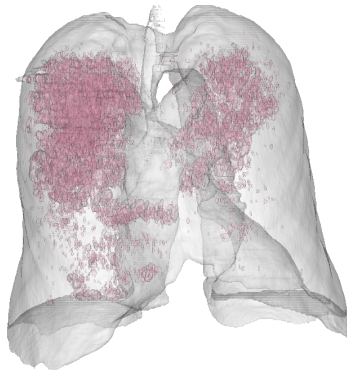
Three-dimensional Visualization of Emphysema Index. Left) Light shade model of the lungs denoting relatively mild emphysema Right) Light shade model of the lungs denoting relatively severe emphysema. Emphysematous regions within the lung field are denoted by opaque shading where the volume in image spaces fall below the specified threshold for the emphysema index calculation. As emphysema progresses, more volume within each CT scan is occupied by emphysematous regions. The volume computed is effectively equal to the computation of emphysema index over the entire image space.
